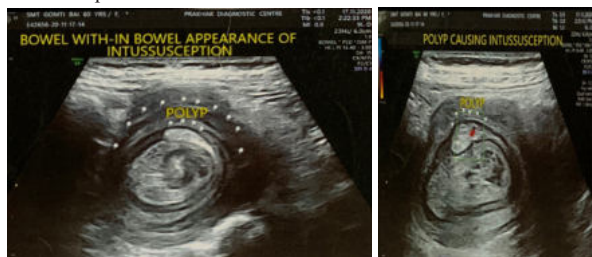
depicting Ultrasound Findings of Duodenojejunal intussusception due to polyp
